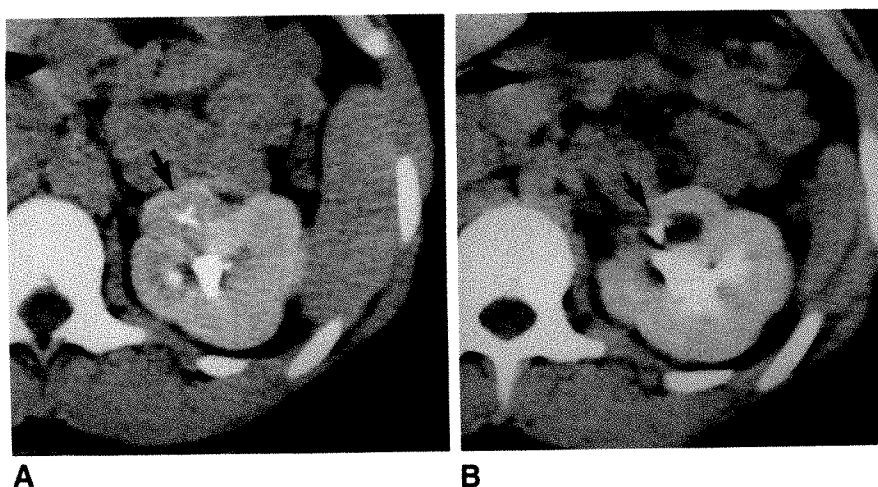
A and B, Enhanced CT scans show an anteriorly located left-upper-pole moiety (arrows). This 10-year-old girl with continuous dribbling of urine had had a normal urogram at age 5 and a normal urogram and sonogram at age 10.
